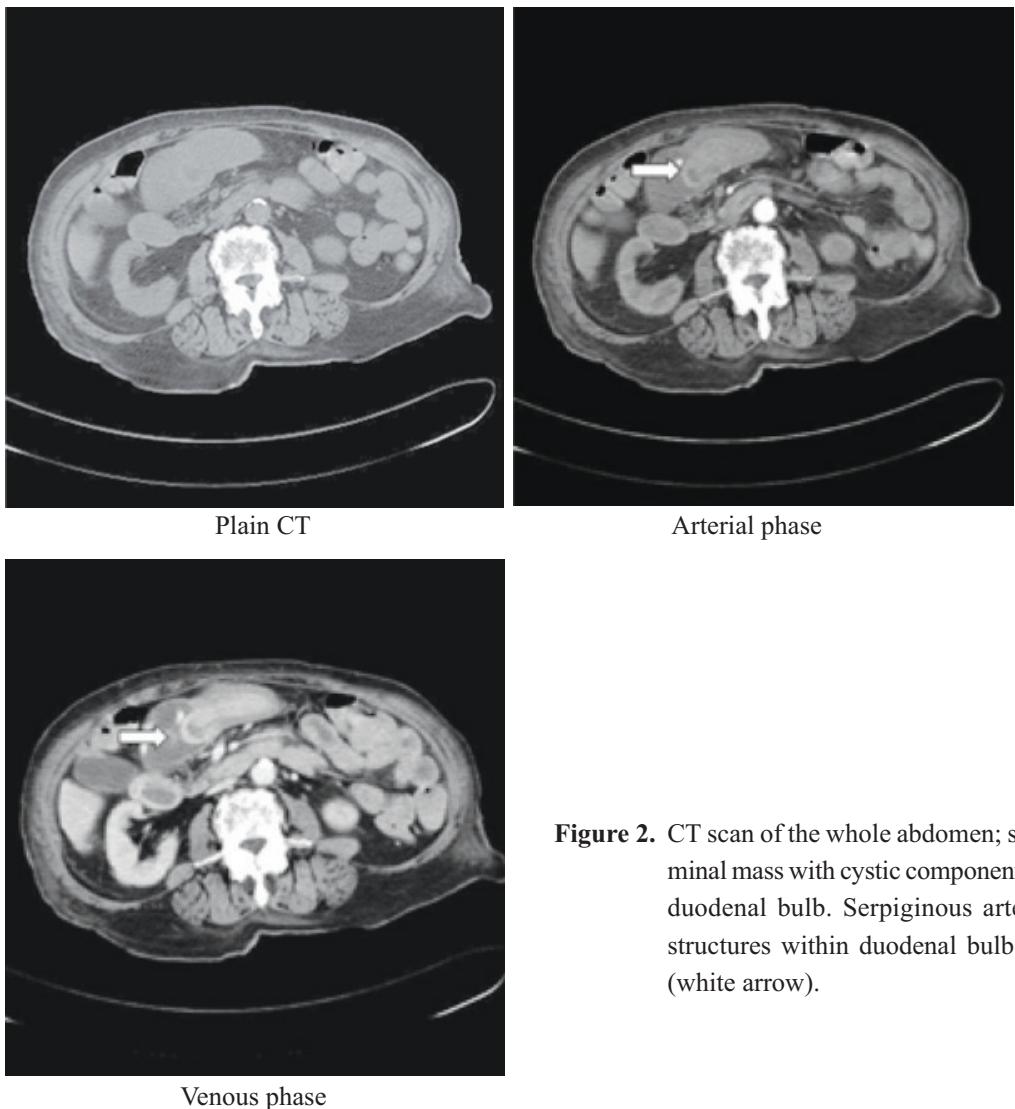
CT scan of the whole abdomen; showing intraluminal mass with cystic component protruding into duodenal bulb. Serpiginous arterial enhancing structures within duodenal bulb were observed (white arrow).
